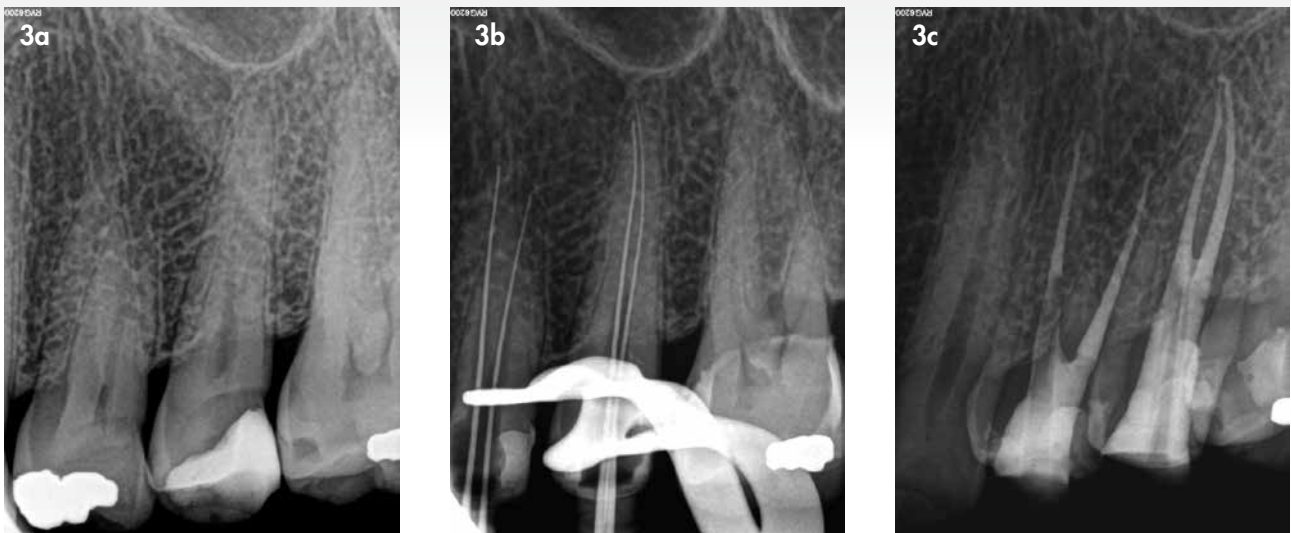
(a) Pre-operative periapical radiograph of non-vital maxillary right first and second premolars; (b) Length determination periapical radiograph; (c) Postoperative periapical radiograph showing the result after obturation and core build-up with fibre posts (X.Posts, Dentsply Sirona) and Core.x Flow (Dentsply Sirona)
